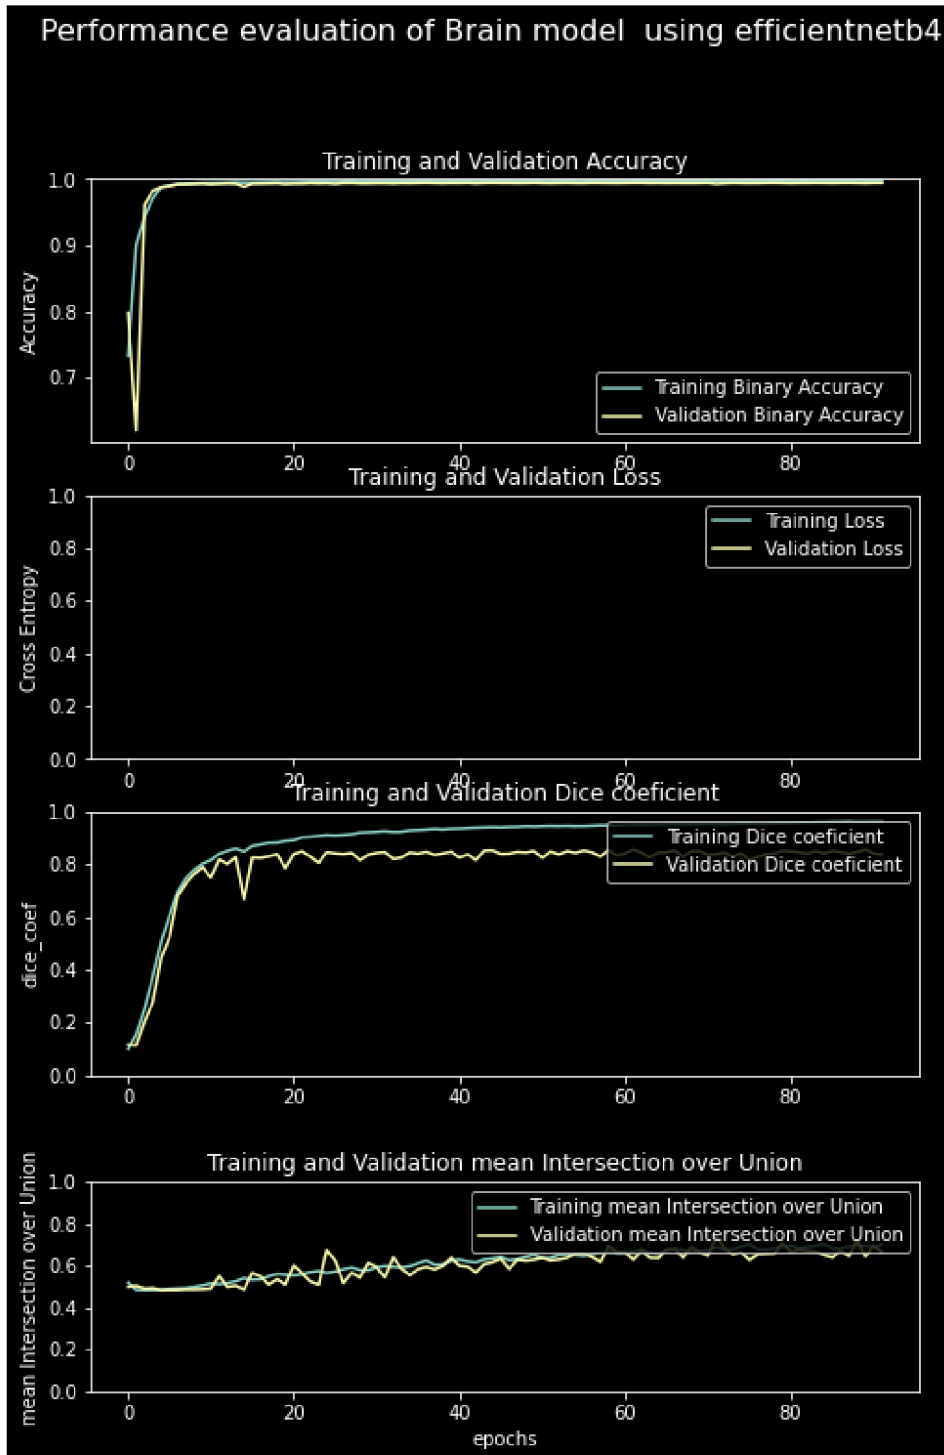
Performance of the custom u-net model using Efficientnetb4 backbone on Brain MRI images. Note the epoch (abscise) graduation with 1 unit = 20 epochs to show the different intersections of the learning and validation curves due to the gradual change in the learning rate up to 0.0001. (Own work).
